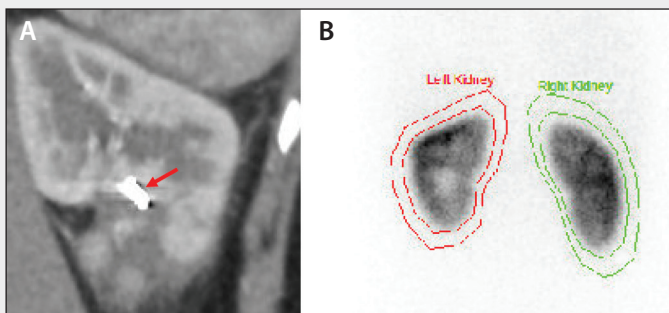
Follow-up CT performed at 6 weeks showing no recurrence of the pseudoaneurysm and stable position of the Ruby Coil (red arrow) (A) and a DSMA scan demonstrating equal preserved renal parenchymal tracer uptake (B).
